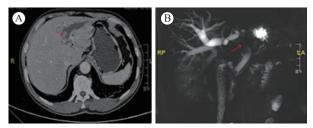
A: Contrast-enhanced CT image of type 1 IPNB; B: MRCP 3image of type 2 IPNB
